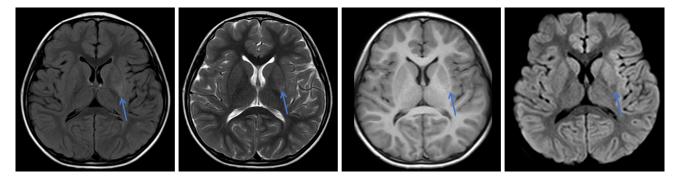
Brain Magnetic Resonance Imaging (MRI) on February 4, 2022 (8 years and 5 months). Abnormal signal (blue arrow) in the posterior left lenticular nucleus: small abnormal signal on slightly high on T2 Weighted Imaging (T2WI), T2-Fluid Attenuated Inversion Recovery (T2-FLAIR), and T1 Weighted Imaging (T1WI), and slightly low on Diffusion Weighted Imaging (DWI), with unrestricted diffusion. (From left to right is T2W1, T2-FLAIR, T1WI, DWI.)
